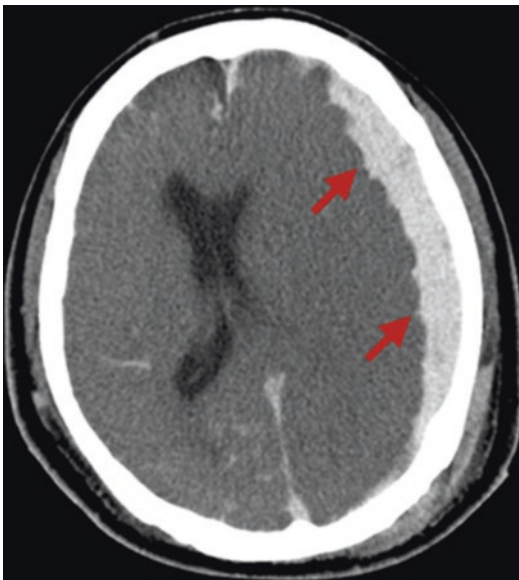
Axial brain computed tomography image of the typical acute subdural hematoma. A crescent-shaped high-density area indicated by arrows is compatible with acute subdural hematoma complicated with localized subarachnoid hemorrhage and subfalcine herniation
